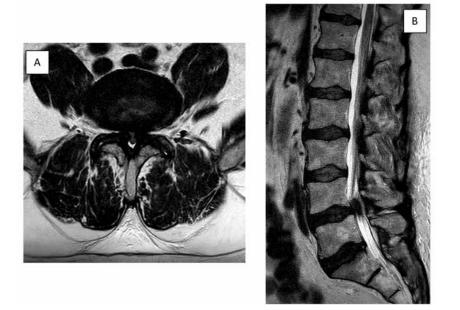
A. Axial T2 MRI demonstrating a progression in central stenosis at the L4-L5 level (September 2020). B. Sagittal T2 MRI demonstrating the well-defined lesion at the L4-L5 disc space (September 2020). MRI, magnetic resonance imaging.
